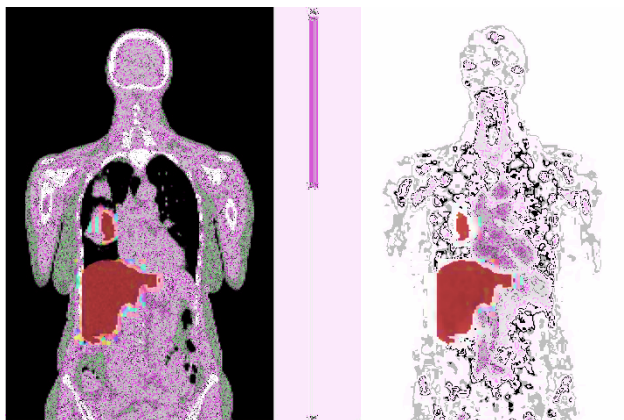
Low-dose CT and PET example patient 4 images in coronal view. The AI-based volume segmentation represented in red, corresponds to the liver.
